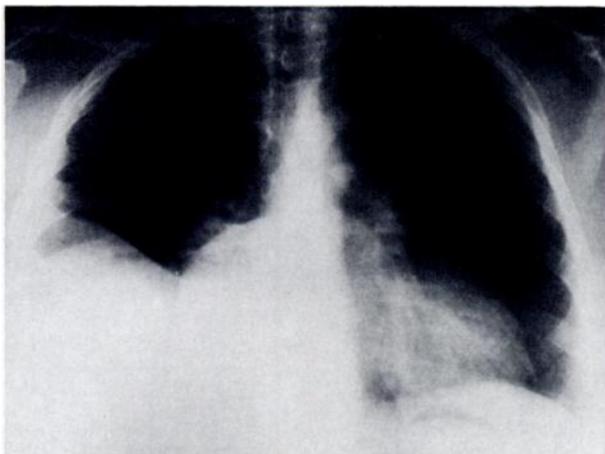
Chest radiograph demonstrating a large right pleural effusion and cardiomegaly.
